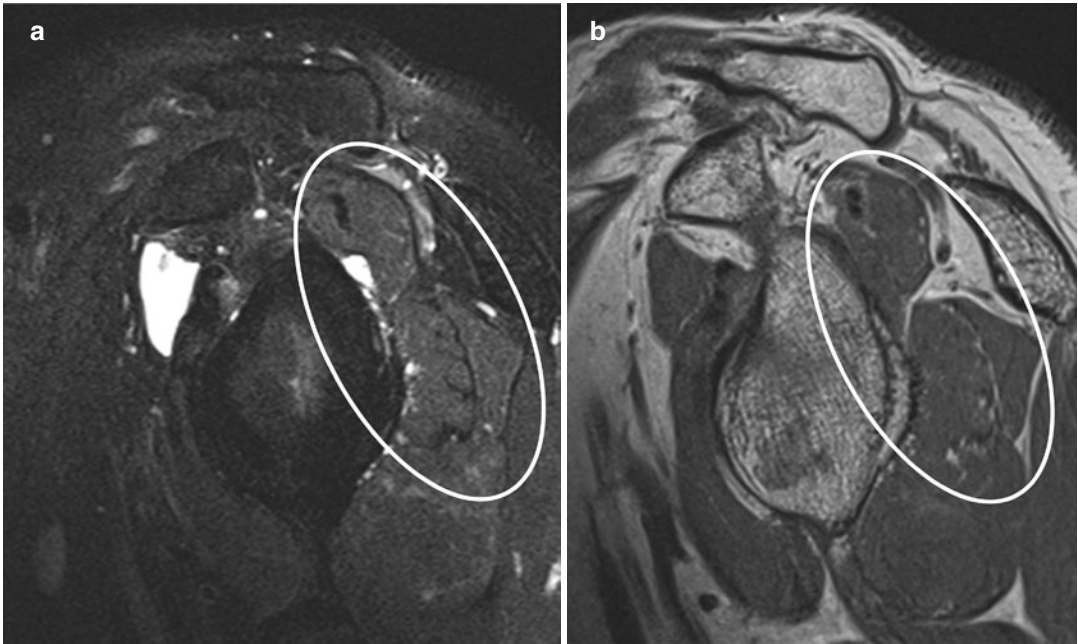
Rotator cuff denervation. Sagittal oblique (a) T2-weighted fat-suppressed and (b) T1-weighted images of the shoulder demonstrating faint denervation edema-like changes and mild fatty infiltration of the supraspinatus and infraspinatus muscles (circled) as a result of suprascapular nerve impingement by a paralabral cyst in the suprascapular notch (not visualized)
